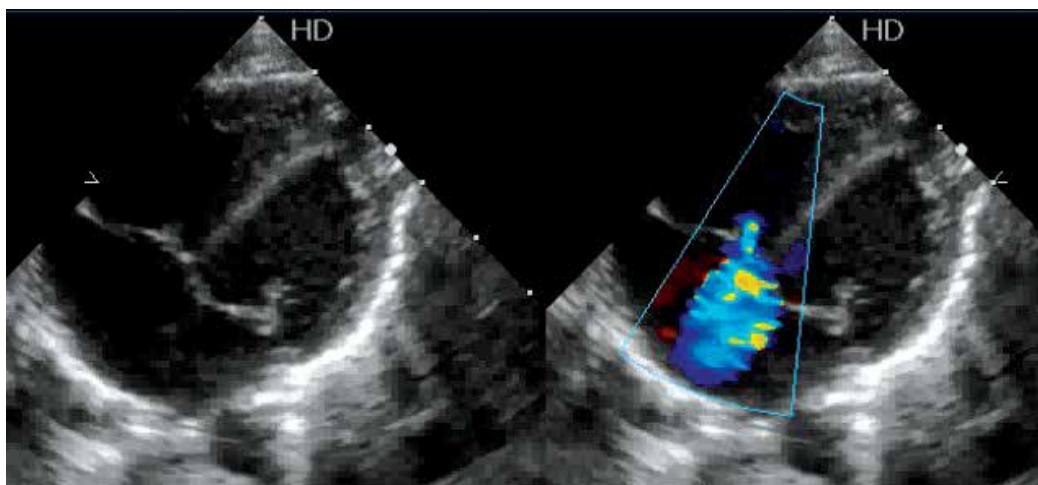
Echocardiographic apical four-chamber image demonstrating a tricuspid regurgitation (blue jet from right ventricle to right atrium).
